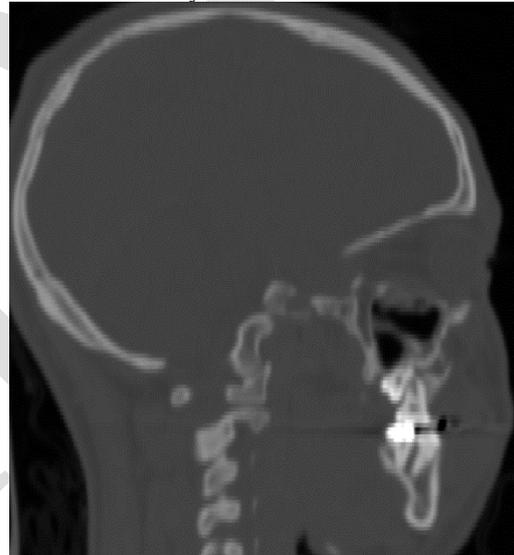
Radiographic picture showing preoperative Computed-Tomography Scan (sagittal Cut).
